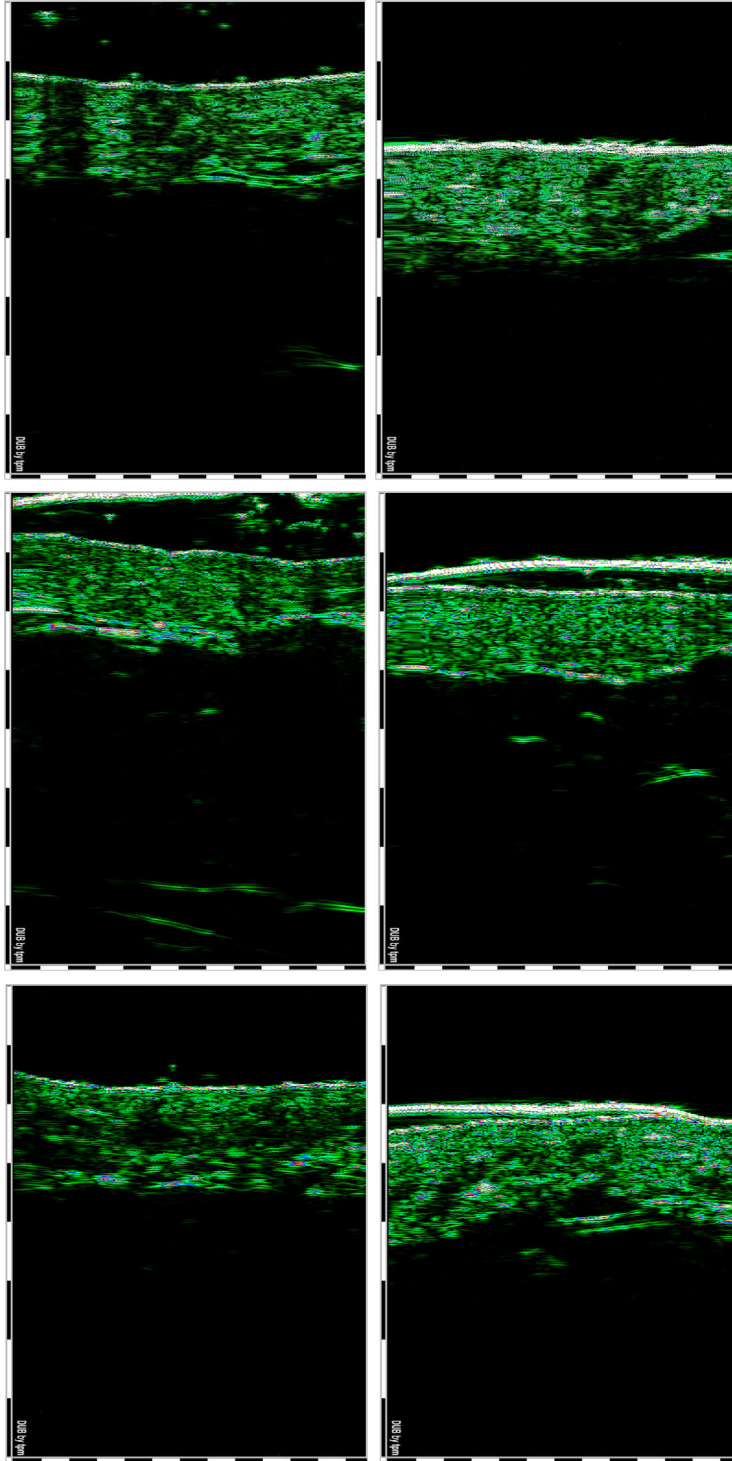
Ultrasonographic aspect of SD before laser treatment (left) and 6 months after treatment (right), 22 MHz transducer, B-scan. Ultrasound investigation of the skin revealed the reduction of hyperechogenic areas of the dermis and the improvement of dermis density (it indicates some increasing structural elements, indirectly the number of collagen fibers).
